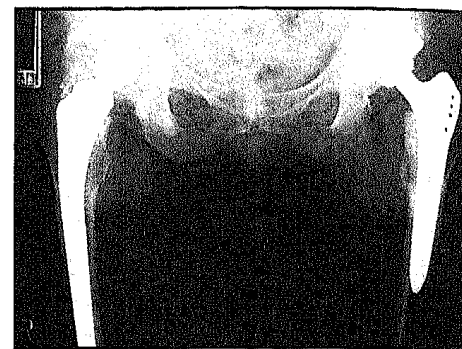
Radiograph of a 64-year-old woman at high risk for heterotopic ossification (grade IV heterotopic ossification in the right hip from previous surgery without indomethacin prophylaxis) demonstrates no heterotopic ossification on the left side with indomethacin prophylaxis after 12 months of follow-up.
